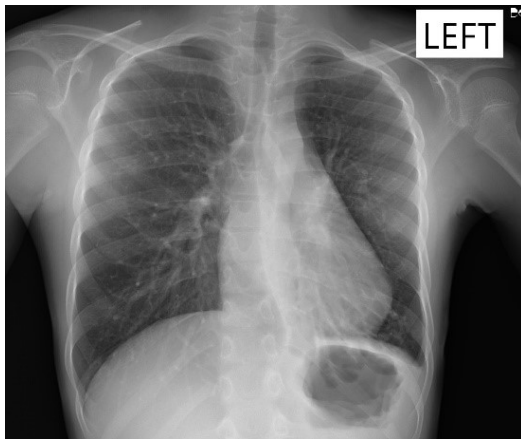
Chest X-Ray done 6 months after the intervention
